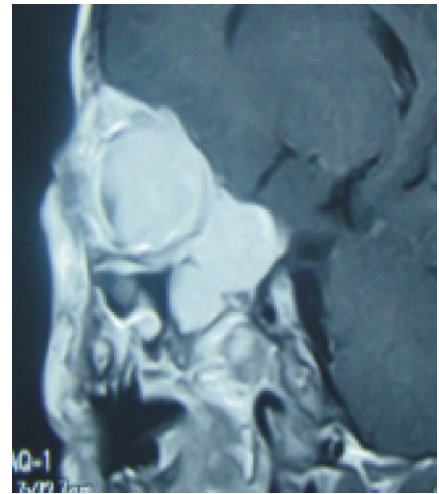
Contrast Sagittal MRI.*
